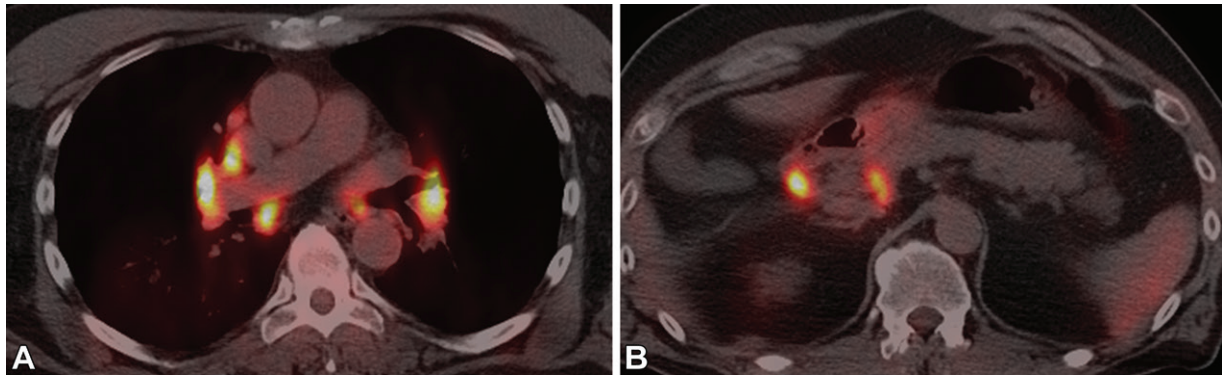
SLG with lymphadenopathy in a 67-year-old man with metastatic melanoma that was treated with checkpoint inhibitor immunotherapy (ipilimumab plus nivolumab). Transaxial FDG PET/CT images obtained at the levels of the mid thorax (A) and upper abdomen (B) to monitor treatment response show new hypermetabolic bilateral hilar, mediastinal, and periportal lymphadenopathy. Subsequent biopsy of bilateral hilar and right paratracheal lymph nodes showed granulomatous inflammation consistent with SLG.
